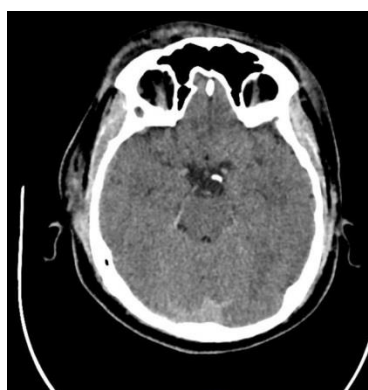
CT Brain showing intracranial haemorrhage.
